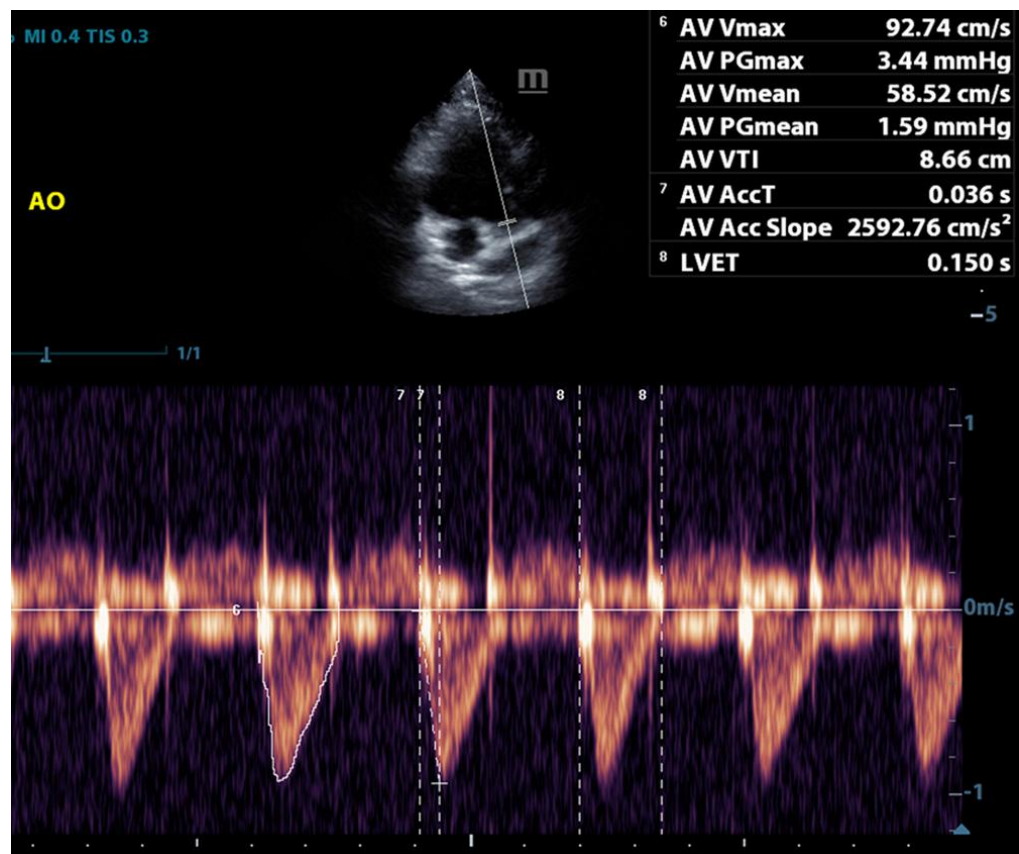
From the left side of the parasternal apical five-chamber view, the echocardiographic Doppler parameters of the aorta are measured. Vmax: peak velocity; PGmax: peak pressure gradient; AV AccT: Acceleration time (AT); LVET: left ventricle ejection time (ET). The AT / ET ratio is 0.24.
